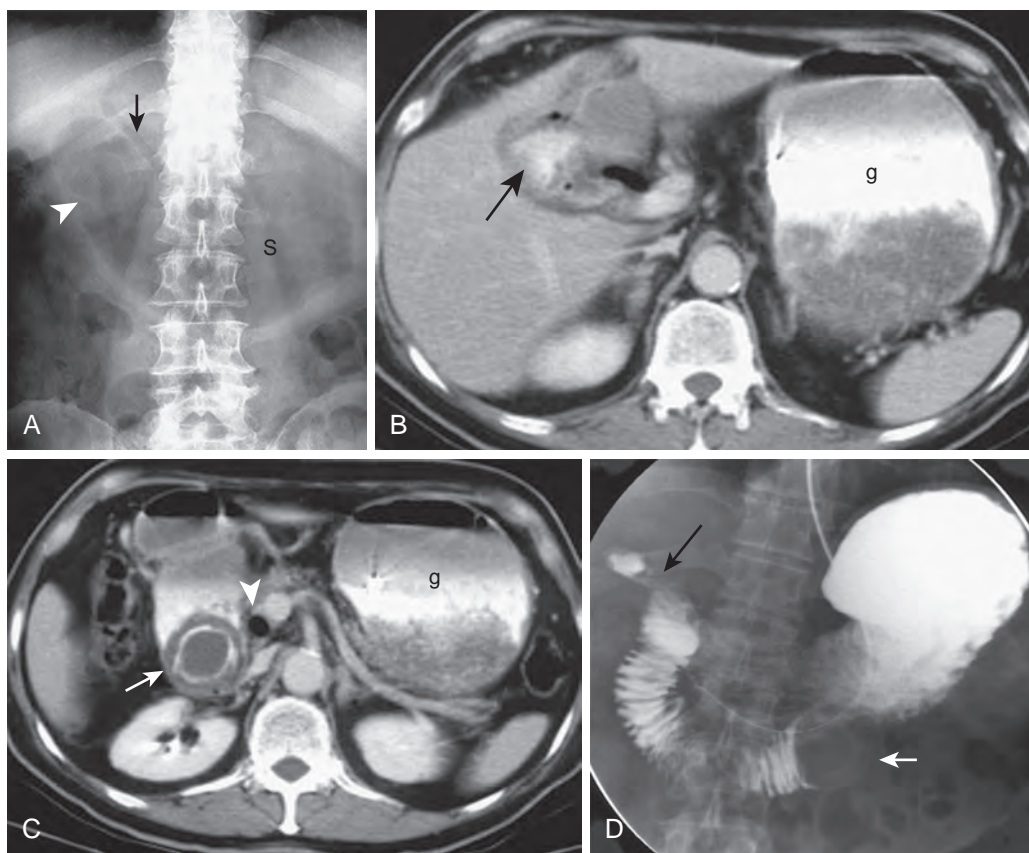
Gallstone ileus: Bouveret's syndrome. A. Abdominal radiograph demonstrates dilated, gas-filled stomach (S). Rounded calcified density (arrowhead) represents a large stone in the region of the distal gastric antrum. There is pneumobilia (arrow). The presence of bowel obstruction, pneumobilia, and obstructing gallstone constitutes Rigler's triad. B. Oral and intravenous contrast-enhanced CT demonstrates distended, contrast-filled stomach (g) consistent with gastric outlet obstruction. There is oral contrast material and bubbles of air in gallbladder fossa (arrow) consistent with cholecystenteric fistula. C. Slightly more inferior CT image demonstrates large obstructing gallstone (arrow) within the proximal duodenum. Air is also present in the CBD (arrowhead). D. Upper gastrointestinal series demonstrates stone as large filling defect that has migrated to duodenal-jejunal junction (white arrow). Fistula between the gallbladder and proximal duodenum is also demonstrated (black arrow).
